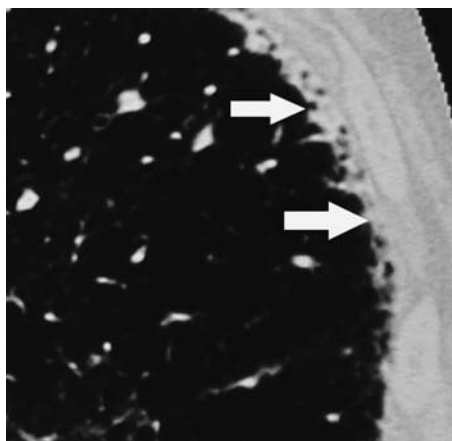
Coned thin-section computed tomography in a different individual showing more extensive disease where there are more confluent pleurally based nodules (arrows)
